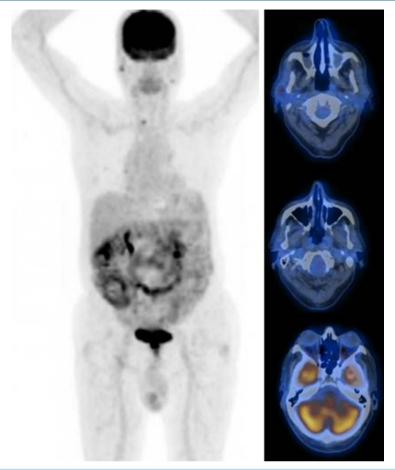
Staging FDG PET/CT performed after the removal of the ENB in the nasal cavity. There are no hypermetabolic lesions, indicative of local recurrence/residual tumors or distant metastases. A small focus of moderately increased activity is noted in the thyroid region.
